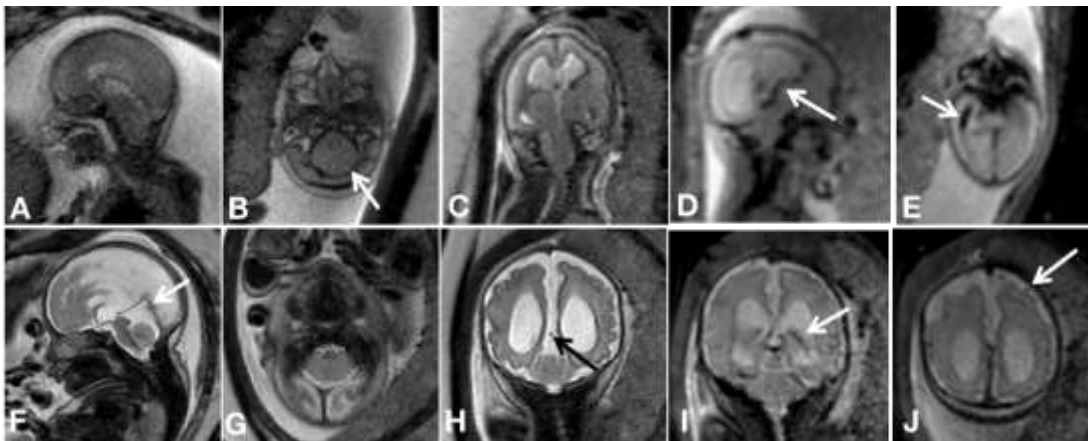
The protective efficacy of intrauterine repair surgery on the venous system. A-E: MRI of a fetus with Chiari II malformation and brain edema at 21GW, showing almost depleted outer CSF space (“dry” brain), very crowded posterior fossa, and transverse sinus stenosis (arrow), resulting in venous congestion (arrow) and white matter edema, as well as ependyma hemorrhage at the right occipital horn shown on EPI -T2* sequence. F-J: A follow-up fetal MR exam was performed at 31+4GW after in-utero surgery, which led to an expansion of outer CSF spaces and presumably reestablishment of proper CSF dynamics, and consequently, improved brain edema. It is noteworthy that the hemorrhage disappeared, and the venous system, including both the deep veins and cortical veins, appears to be functioning normally in this follow-up examination.
